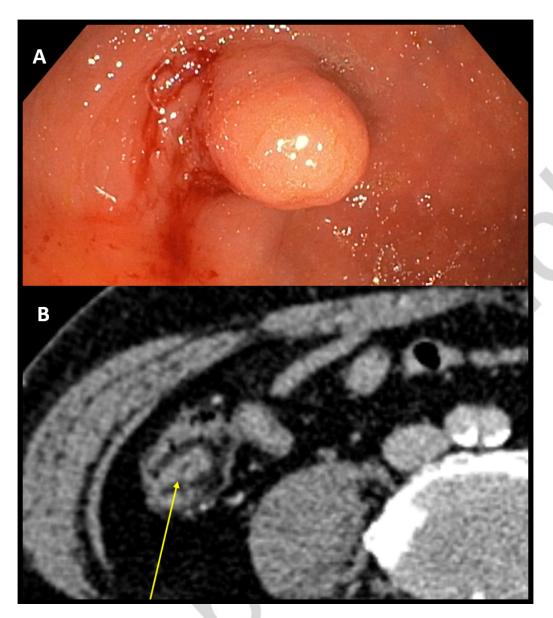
A. Colonoscopic view of a 2 cm long and 1 cm wide polypoid mass occupying the appendiceal orifice. B. Multislice computed tomography (MSCT) of the abdomen demonstrating a cecal intraluminal tubular structure.
